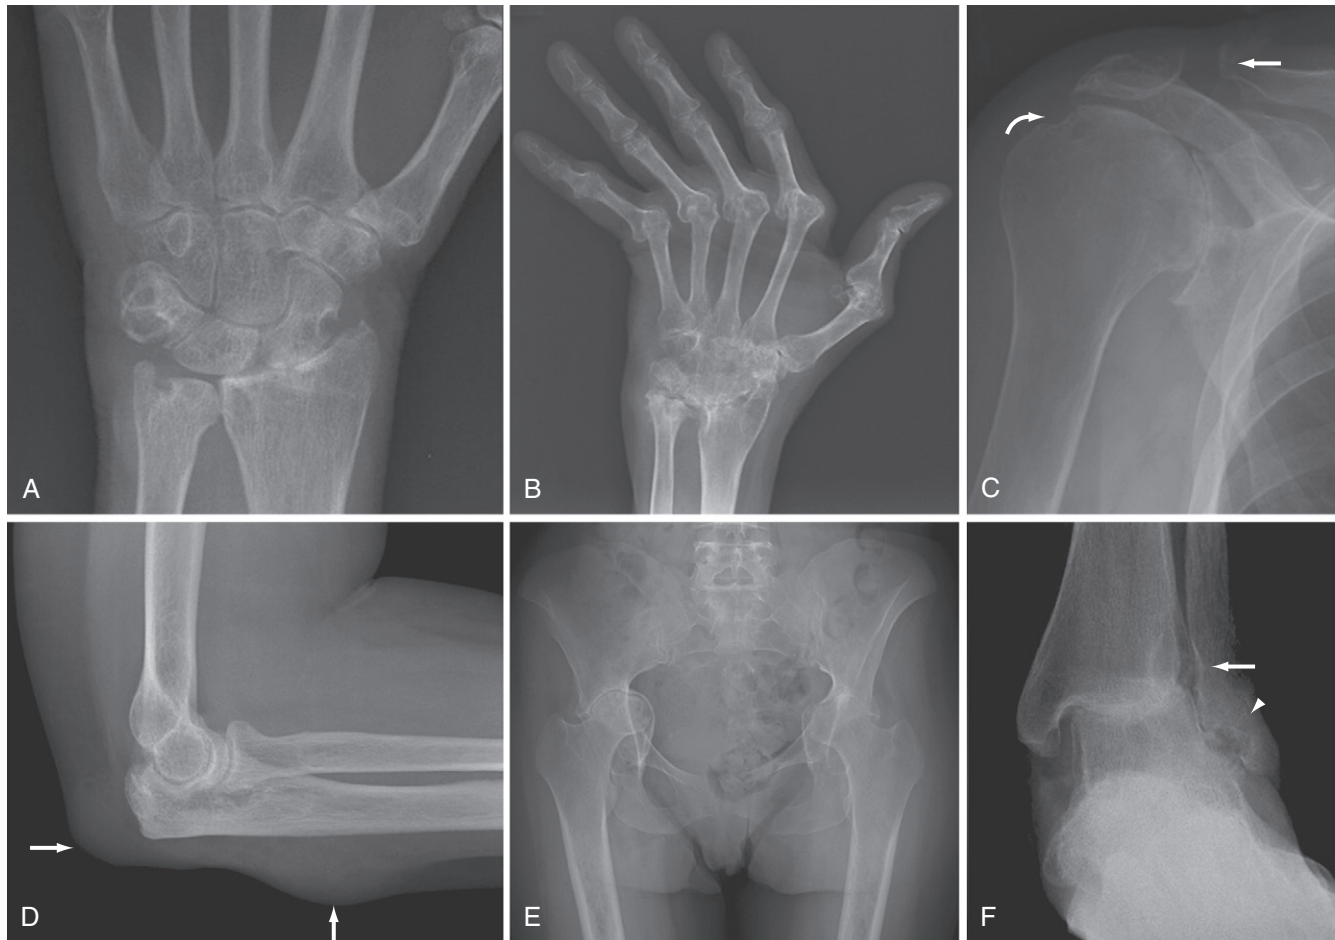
Rheumatoid arthritis (x-ray). A, Multiple typical bone erosions are seen (e.g., in triquetrum, pisiform, scaphoid, radius, and ulnar styloid process). Diffuse cartilage loss also is evident in the radiocarpal compartment. B, Severe ulnar deviation is present at the metacarpophalangeal joints with extensive erosions. Severe erosion and bony ankylosis are seen in the wrist. C, Posterior oblique view of a shoulder shows severe glenohumeral joint space narrowing with marginal erosion and cystic change of the humeral head adjacent to the greater tuberosity (*curved arrow*). Elevation of the humeral head with respect to the glenoid indicates chronic rotator cuff tear. Tapering of the distal end of the clavicle and widening of the acromioclavicular joint (*straight arrow*) are also evident. D, Rheumatoid nodules appearing as lobulated subcutaneous soft tissue swellings (*arrows*) at the extensor surface of the elbow and forearm. E, Bilateral protrusio acetabuli. The medial acetabular margins protrude into the pelvis. Severe accompanying cartilage loss has occurred. F, Ankle with diffuse loss of cartilage space with erosions of the fibula (*arrow and arrowhead*). The hindfoot is in valgus alignment.
